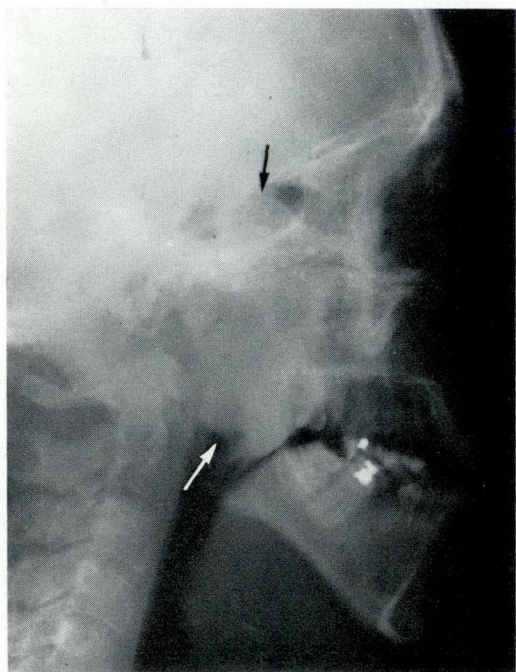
Soft-tissue lateral skull radiograph showing large nasopharyngeal mass involving the sphenoidal air sinus.
